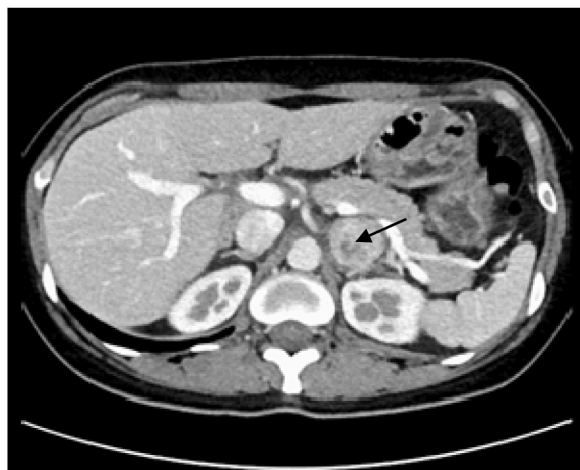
Adrenal contrast-enhanced CT revealed a left adrenal region measuring approximately 26×25 mm, with a CT value 37 Hounsfield units.
